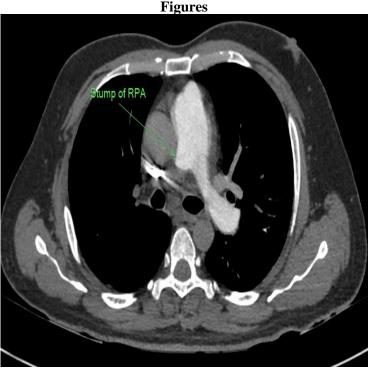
43 year old male with unilateral absence of right pulmonary artery. Axial CT section of pulmonary angiogram demonstrating extremely narrow caliber of right pulmonary artery.
